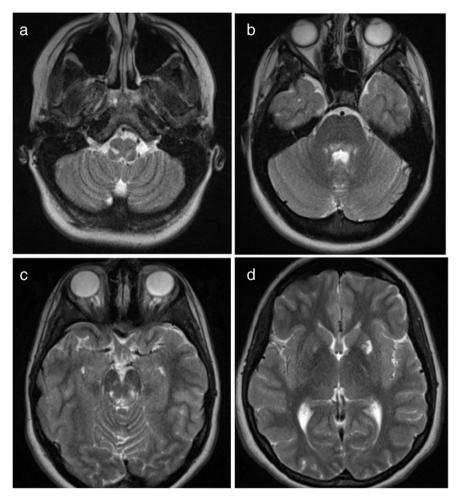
MRI of the brain of the patient showing small foci of hyperintensities in the medulla (a), posterior pons (b), midbrain (c), and basal ganglia (d) bilaterally in T<sub>2</sub>-weighted axial scans.
